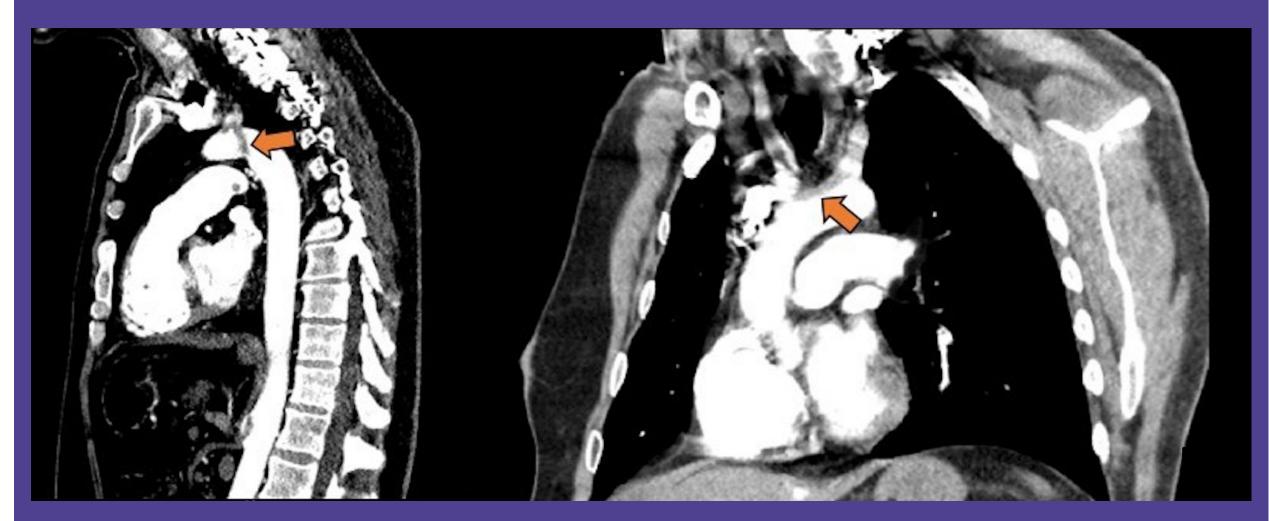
CT scan images from the time of admission. The sagittal view (Left) and the coronal view (Right) show extensive clot burden in the aortic arch extending into the main branches
